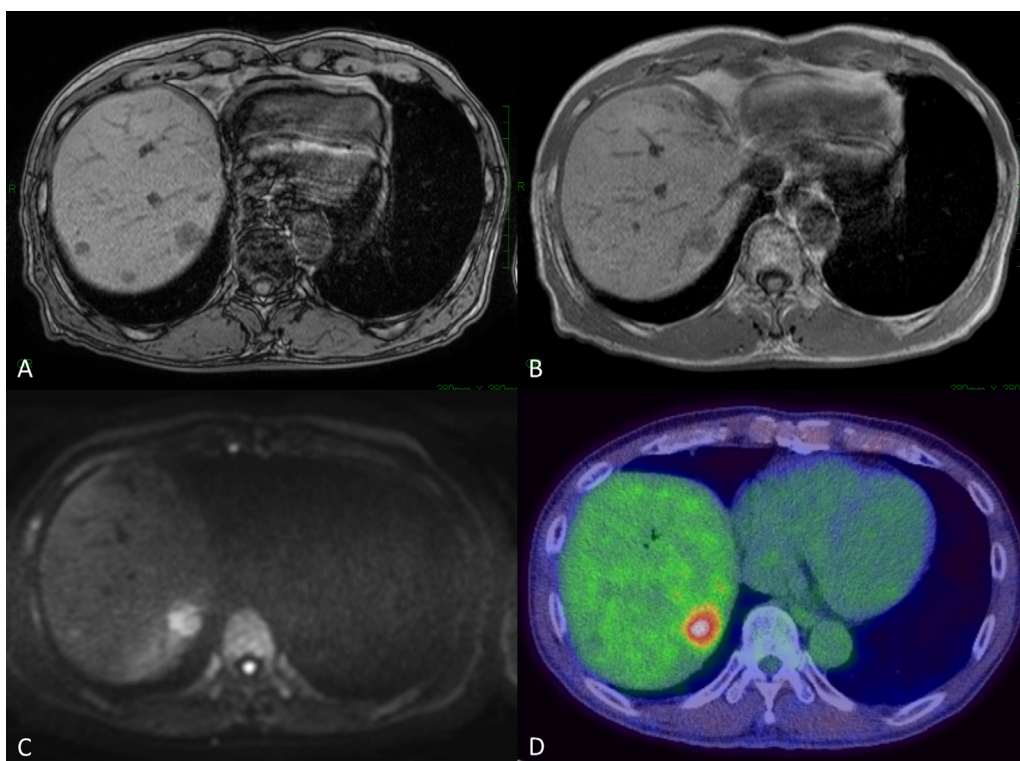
Abdominal magnetic resonance imaging and Positron emission tomography.
